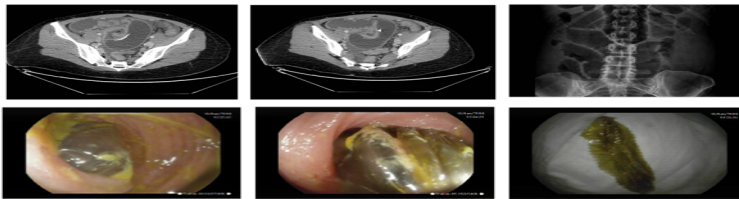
Balloon occluded in the medium ileum. Radiological and endoscopic images. A and B. CT image of the migrated and impacted balloon (with radio-opaque marker) in the middle ileum, causing ileal occlusion. C. Simple abdominal Rx with significant intestinal handle bloating. D. Endoscopic image of a partial intestinal stenosis, conditioning impact of the balloon with ileal handle occlusion. E. Partially emptied balloon after endoscopic tearing of its polyurethane coating and in the ileal extraction pathways. F. Final result of the eliminated balloon.
